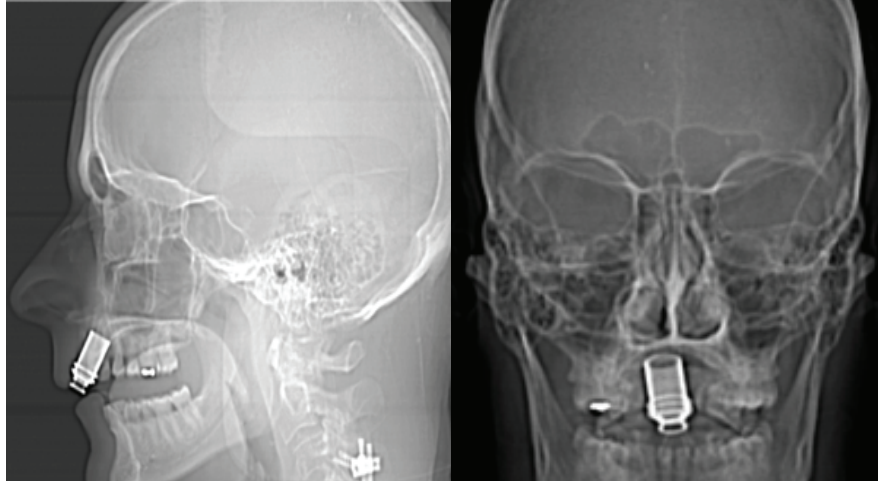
Scout imaging from CT maxillofacial showing metallic foreign body in the anterior midline maxilla.
